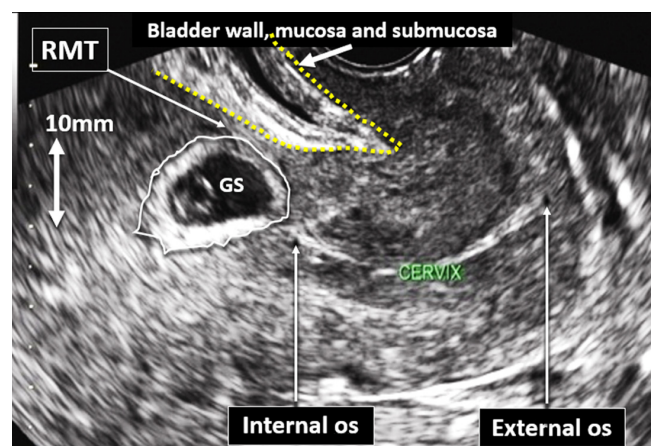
Grayscale transvaginal ultrasound image of Cesarean scar pregnancy, showing enlarged area of cervix and of internal os below bladder (dashed line). Residual myometrial thickness (RMT) between bladder wall and gestational sac (GS) is indicated.
